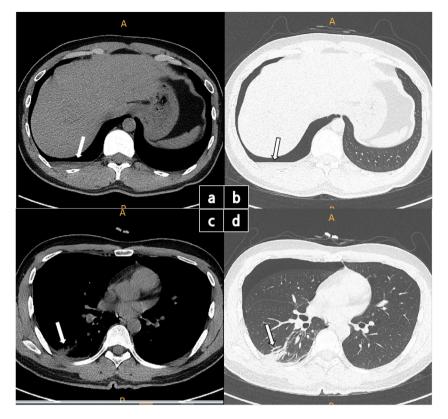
CT scan a b Hemopneumothorax was detected in the patient's lung (S hospital, 10/6). c and d Pulmonary hemorrhage was detected in the patient's lung (S hospital, 10/6).
